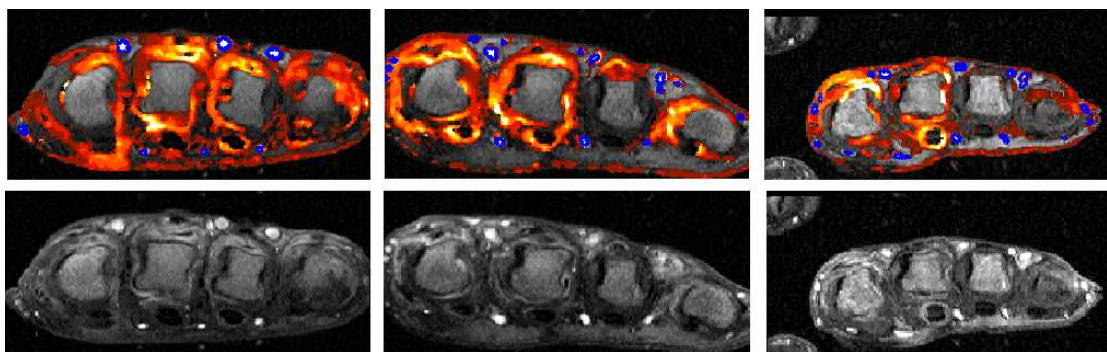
Top: Parametric maps of  $ME$  corresponding to DCE-MRI slices with segmented blood vessels (the contour is shown in blue). Bottom: Corresponding post-contrast images.
